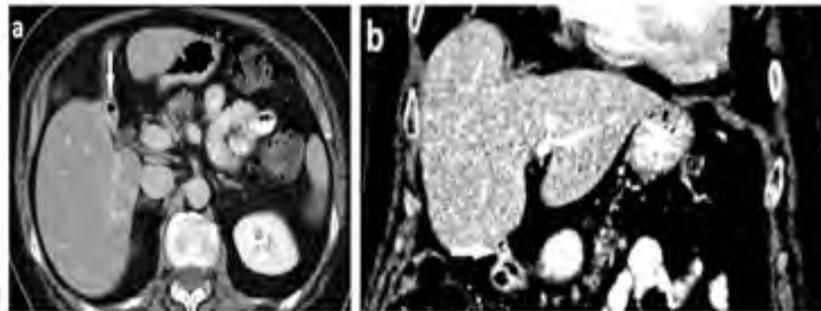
Contrast enhanced computed tomography, (a) axial scan shows pneumobilia (white arrow), (b) coronal scan shows biliobulbar fistula (white arrow).
